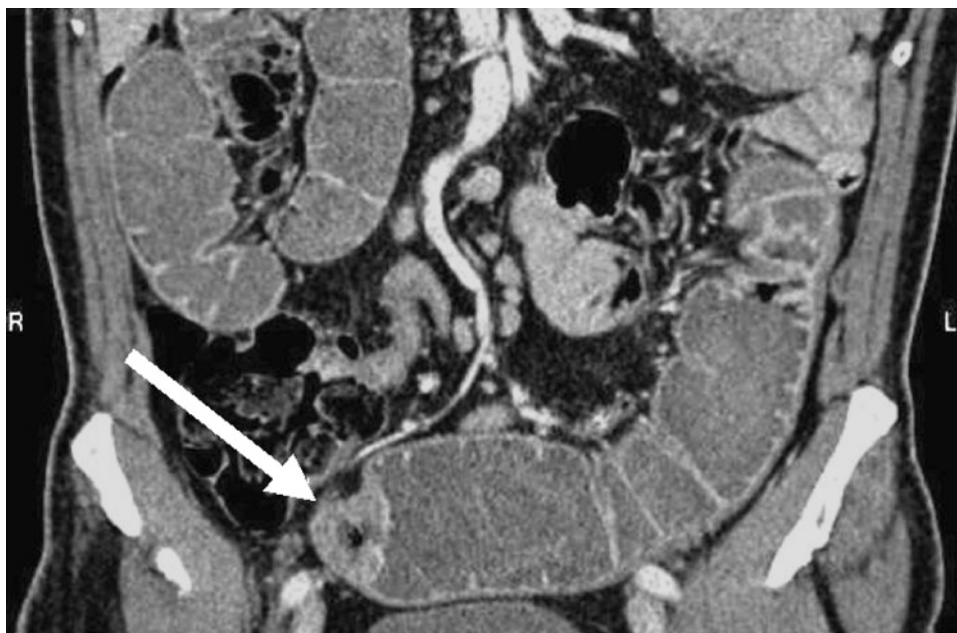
Abdominal CT showing circumferential thickening of the terminal ileum.
